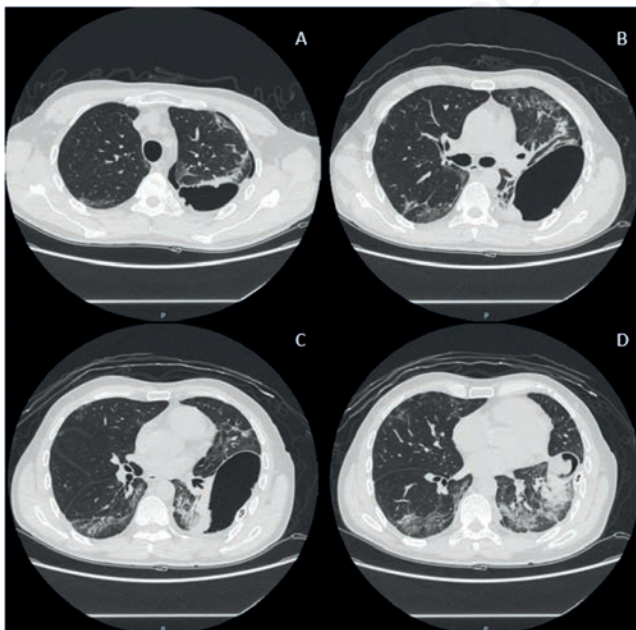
A-D) Computed tomography scan showing the giant bulla in the fissure between the left upper and lower lobes.
